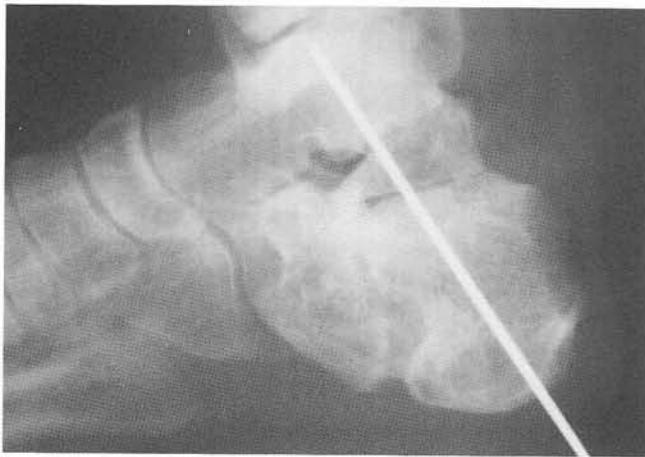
Intraoperative lateral radiograph confirms reestablishment of talocalcaneal relationship.
